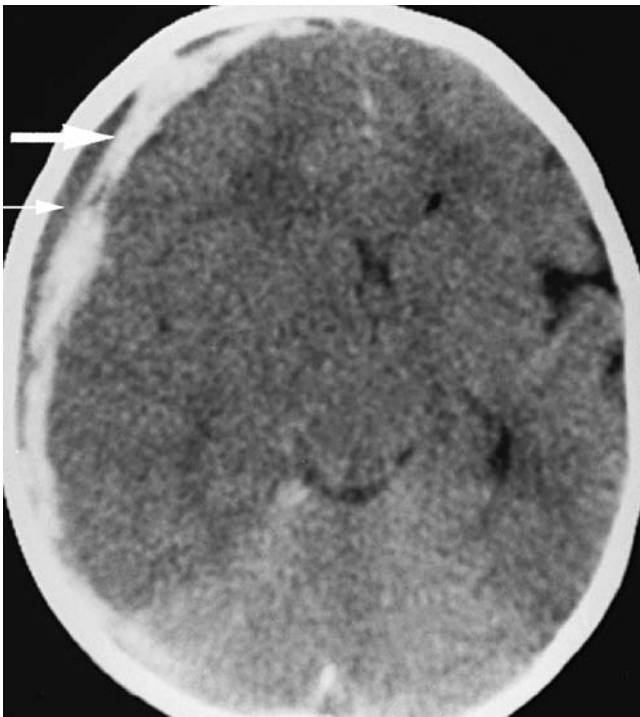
Subdural hematoma (SDH) and brain swelling. This 9-month-old boy reportedly became suddenly unresponsive. There was no history of trauma. On examination, he was comatose with fixed dilated pupils and extensor posturing. Massive bilateral retinal hemorrhages were seen. This head computed tomographic scan shows a right-sided SDH, with acute hyperdense (*thick arrow*) and hyperacute isodense (*thin arrow*) components. Midline shift to the left is noted. There is also evidence of brain swelling, with effacement of the sulci and poor gray–white differentiation. The diffuse hypodensity of the cerebral cortex can be contrasted with the normal density of the cerebellum, which appears whiter in this view. A diagnosis of child abuse was made.
